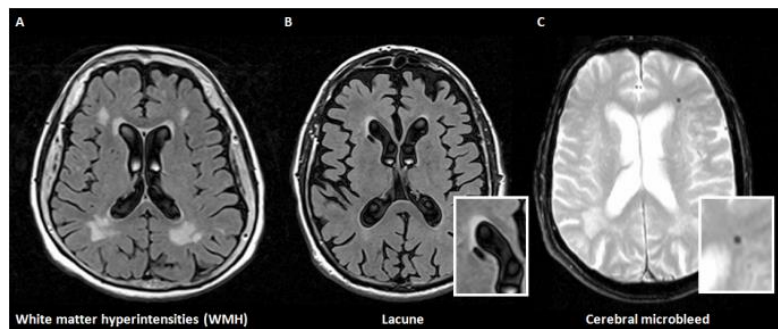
Conventional MRI Brain lesions can include white matter hyperintensities (A), lacunes (B) and microbleeds (C).
